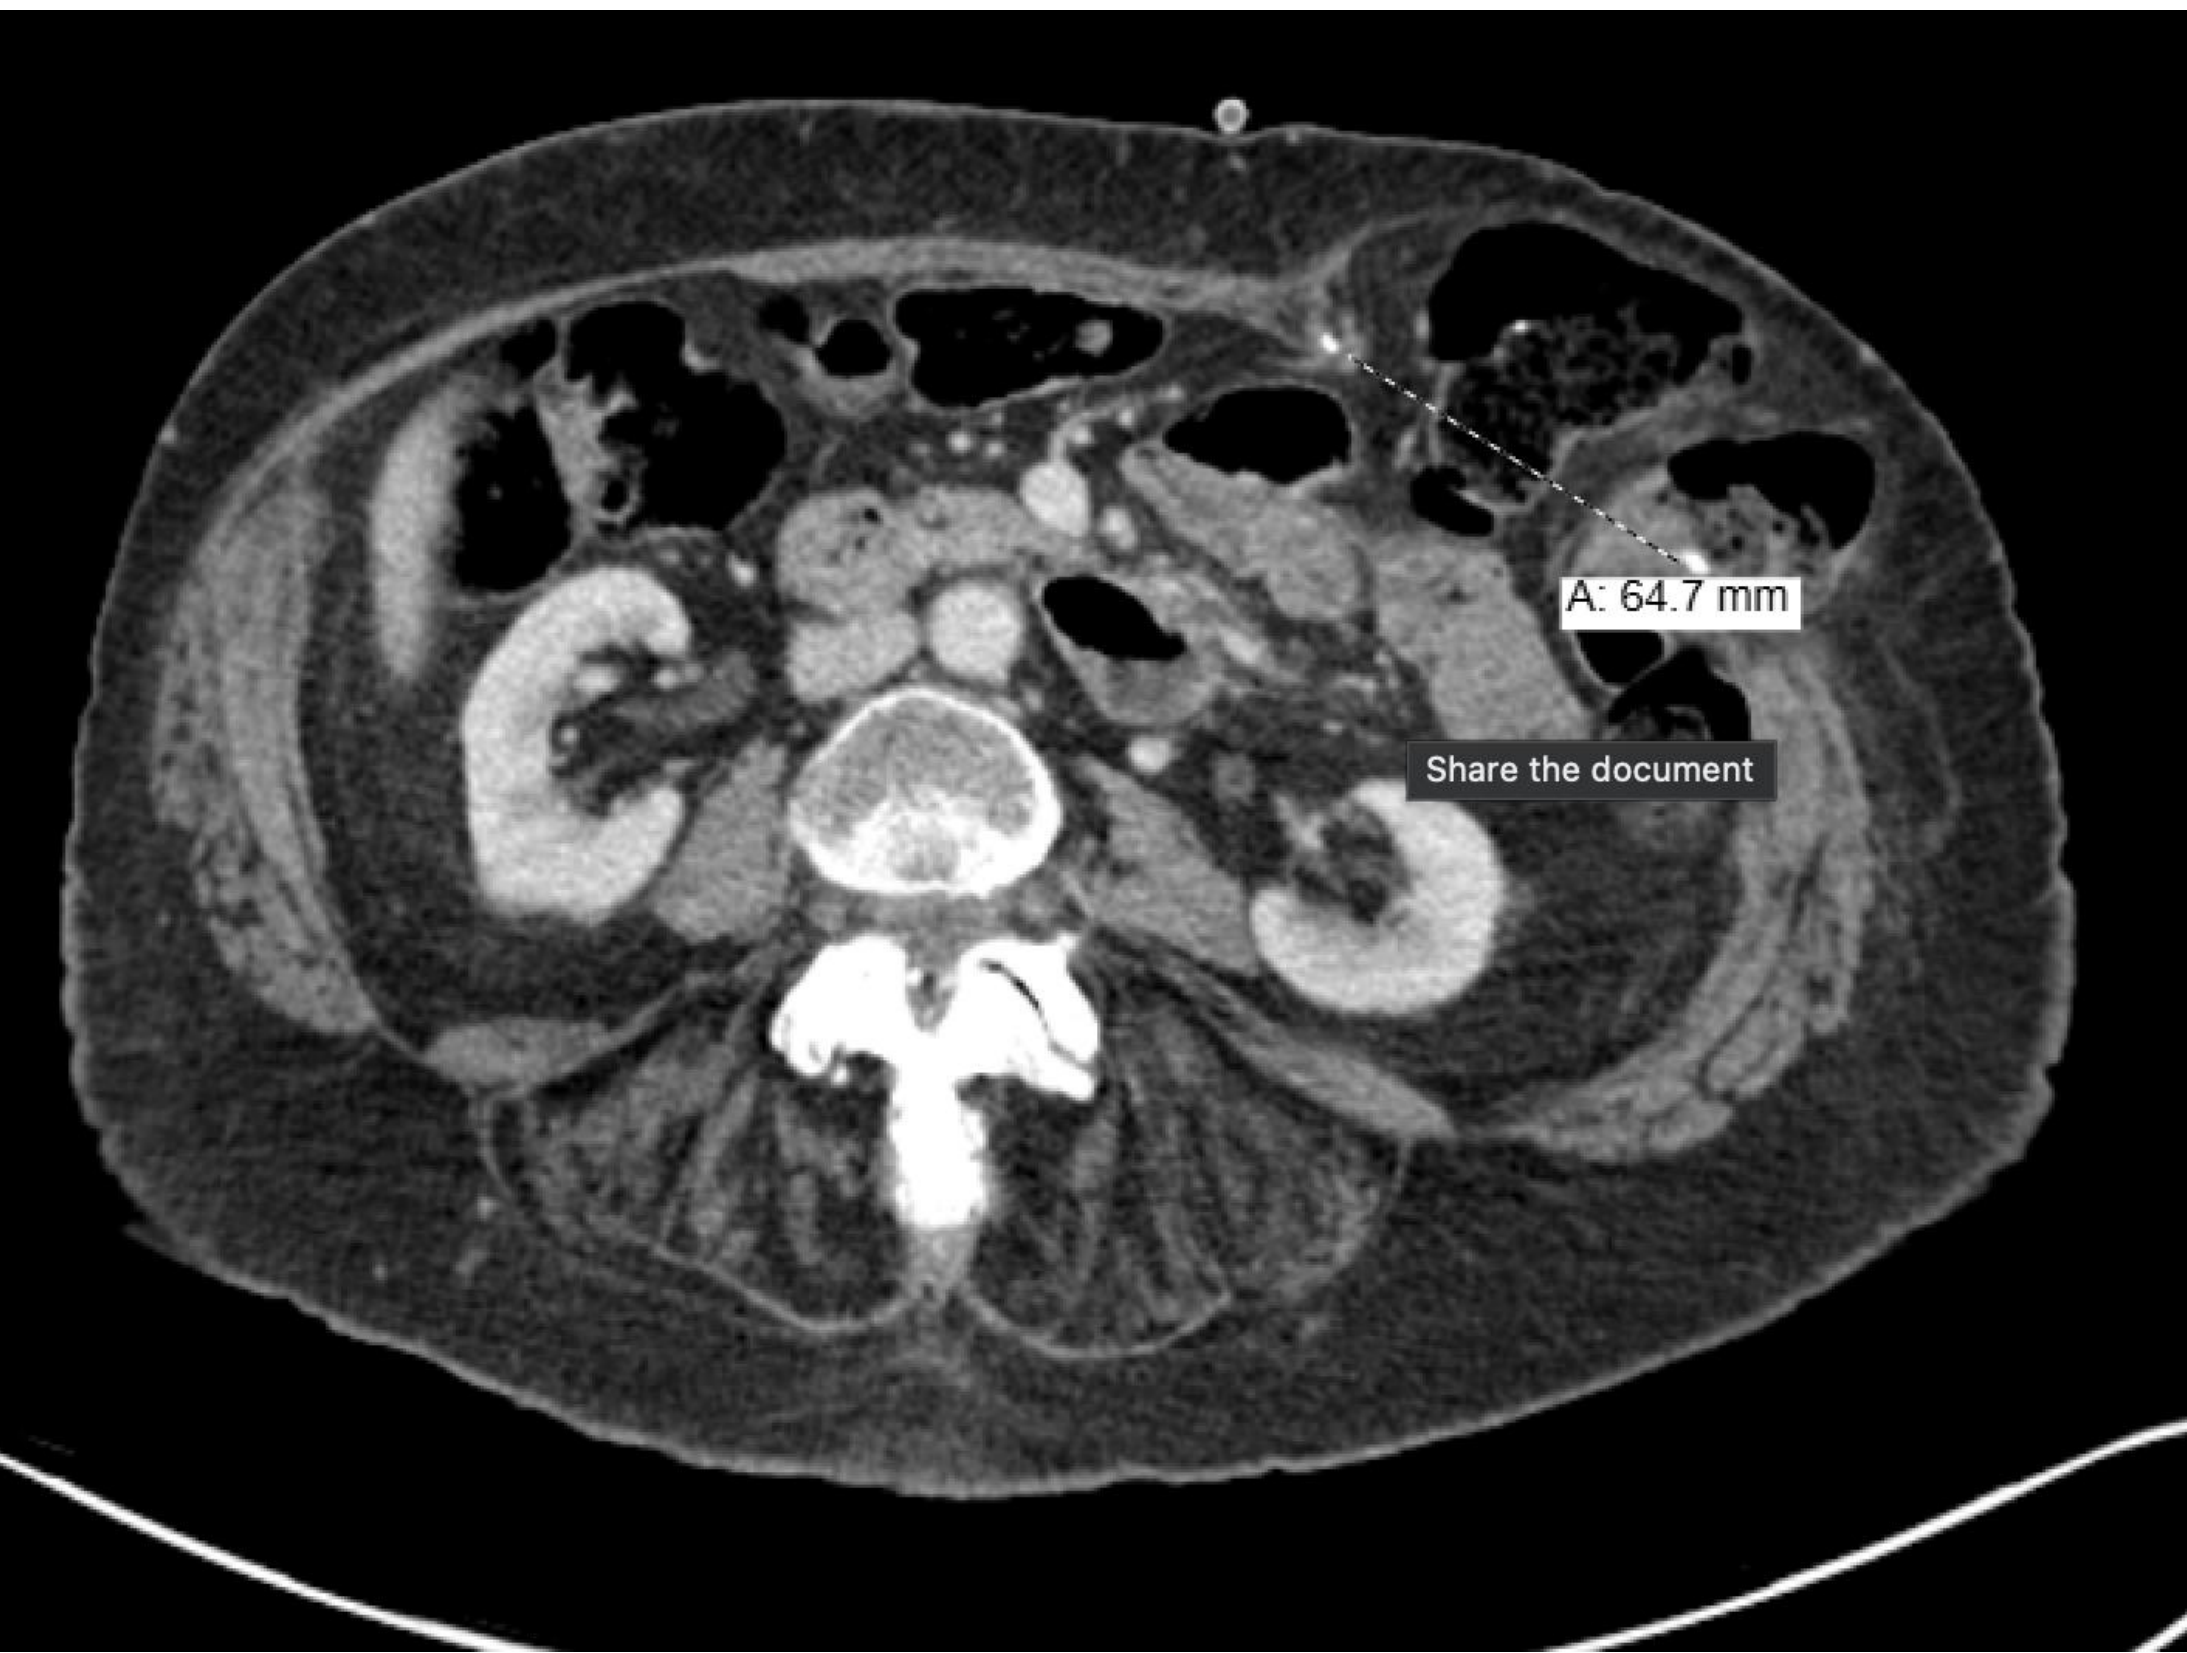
CT Abdomen/ Pelvis with contrast, status post APR with LLQ colostomy. Moderate parastomal hernia containing loops of non obstructed transverse colon. Status post percutaneous gastrostomy tube. No herniation of stomach into the parastomal hernia.
